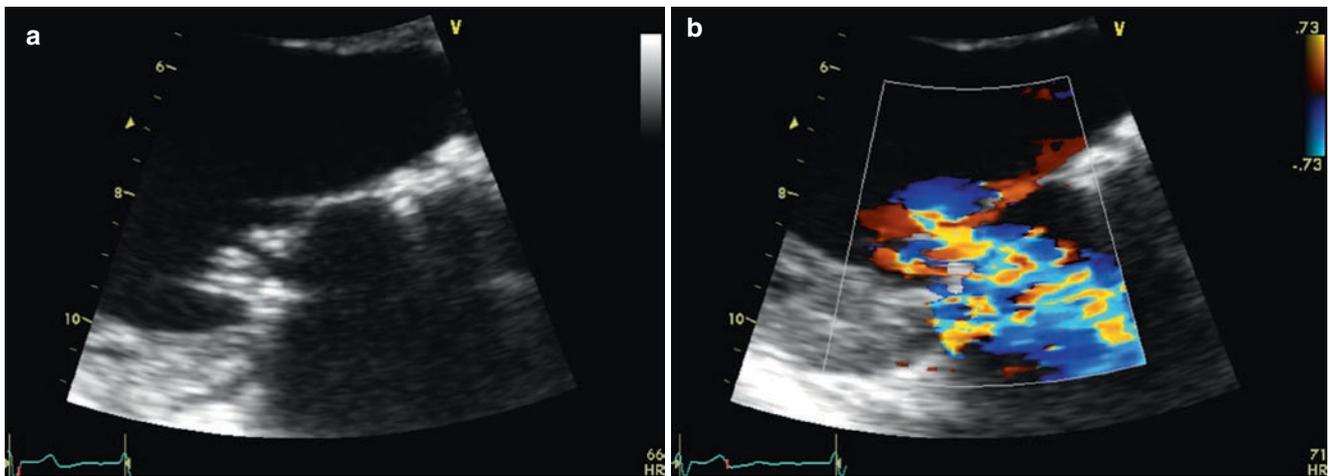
Severe haemolysis in a female patient after mitral annuloplasty. Transthoracic echocardiography (a, b) showed a moderate regurgitant jet directed towards the annular ring, causing fragmentation of red cells and haemolysis
